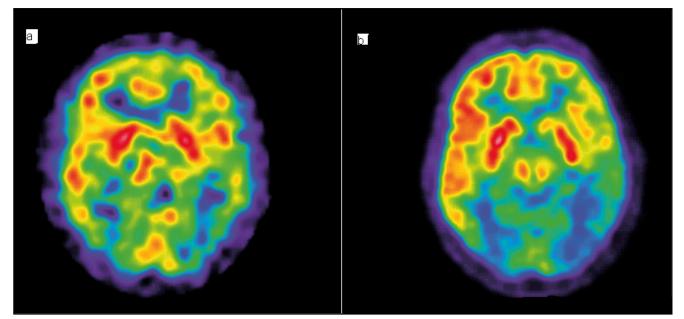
a) Brain perfusion imaging was obtained by 99m-Tc-bicisate-SPECT on an IRIX three-head gamma camera. A rather small perfusion defect on the left occipital cortex can be observed as well as an area of marked hypoperfusion contralaterally.
